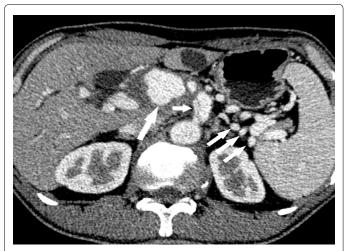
CT finding of the celiac artery dissection.
